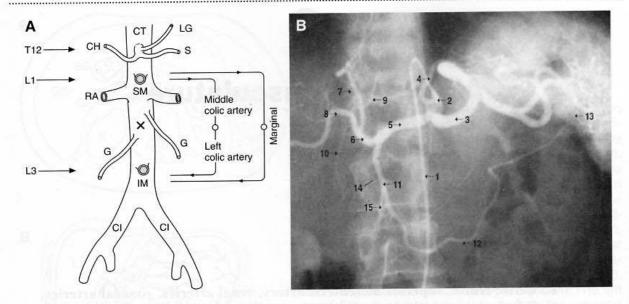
(A) The major branches of the abdominal aorta. The abdominal vasculature has a fairly robust collateral circulation. Any blockage (X) between the superior mesenteric artery (SM; at vertebral level L1) and inferior mesenteric artery (IM; at vertebral level L3) causes blood to be diverted along either or both of two routes of collateral circulation. The first route uses the middle colic artery, which is a branch of the SM artery, which anastomoses with the left colic artery, a branch of the IM artery. The second route uses the marginal artery. CH = common hepatic artery; CI = common iliac artery; CT = celiac trunk; G = gonadal artery; LG = left gastric artery; RA = renal artery; S = splenic artery. T12, L1, and L3 indicate the vertebral levels of the various branches. (B) Arteriogram showing other arteries in the vicinity. 1 = catheter in aorta; 2 = catheter in celiac trunk; 3 = splenic artery; 4 = left gastric artery; 5 = common hepatic artery; 6 = hepatic artery proper; 7 = left hepatic artery; 8 = right hepatic artery; 9 = right gastric artery; 10 = cystic artery; 11 = gastroduodenal artery; 12 = right gastroepiploic artery; 13 = left gastroepiploic artery; 14 = posterior superior pancreaticoduodenal artery; 15 = anterior superior pancreaticoduodenal artery. (A adapted with permission from Moore KL: Clinically Oriented Anatomy, 3rd ed. Baltimore, Williams & Wilkins, 1992, p 168; B adapted with permission from Ryan S, McNicholas M: Anatomy for Diagnostic Imaging. London, WB Saunders, 1994, p 156.)
